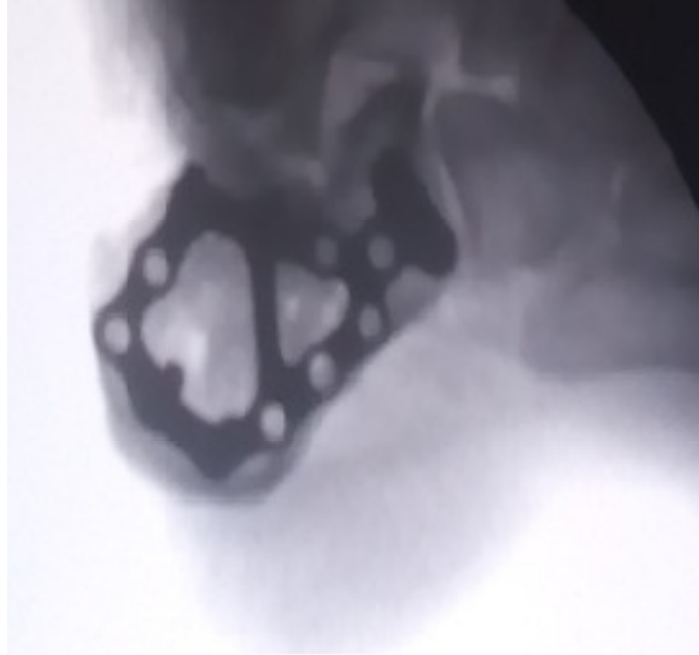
Post operative radiograph showing good placement of the plate
